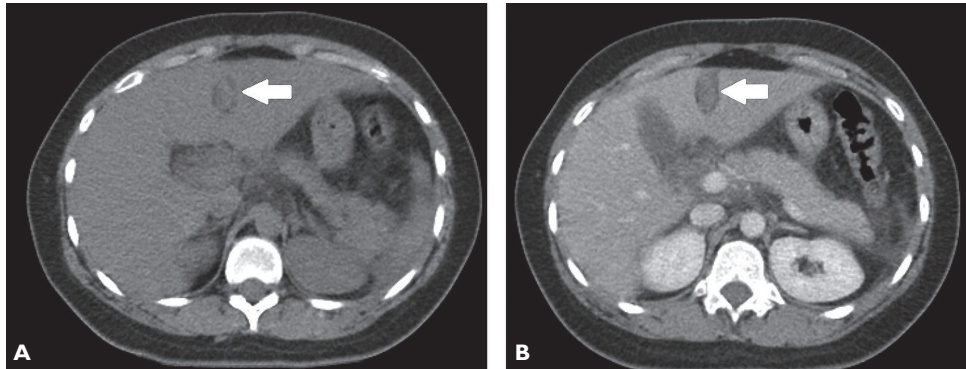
Axial section of computed tomography scan without contrast in A and with contrast in the portal phase in B shows border sign and fatty mass along the falciform ligament, without contrast enhancement, compatible with torsion of the falciform ligament (white arrow).
